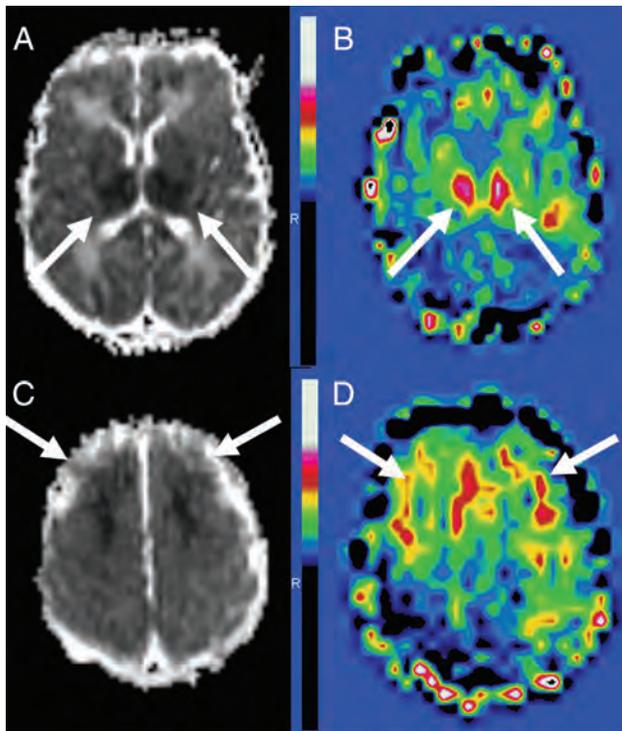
HIE ASL. Asphyxiated neonate treated with hypothermia showing ischemic injury on MR imaging obtained on day 3 of life. The ADC map shows restricted diffusion in the bilateral thalami and lentiform nuclei (A) and in the frontal watershed areas (C) (arrows). ASL perfusion map (B and D) reveals higher perfusion within the same areas (arrows).
